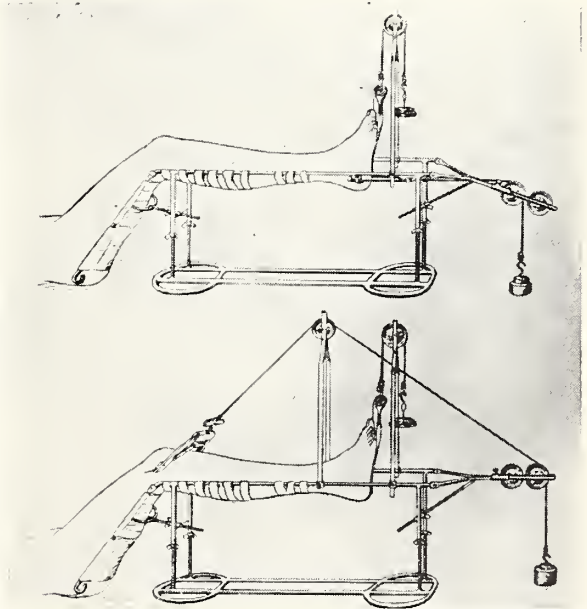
Zimmer modification of Boehler-Braun splint, padding omitted to show detail. Top—for use in lower leg fractures with pin through os calcis. Bottom—for use in fractures of femur. Pin can be inserted through condyles of femur or through upper tibial crest. These are handy splints to have in any hospital and simplify obtaining x-rays by portable machine. (Courtesy Zimmer Manufacturing Company, Warsaw, Indiana.)
